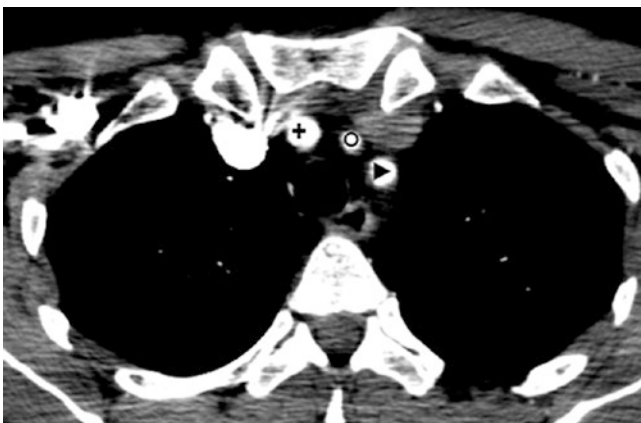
51-year-old with typical origins of the great vessels off of the aortic arch on contrast-enhanced CT. *Aortic Arch* (*curved arrows*); IA Innominate Artery (+); LCCA Left Common Carotid Artery (○); LSCLA Left Subclavian Artery (▶); RCCA Right Common Carotid Artery (●); RSCLA Right Subclavian Artery (◀)
